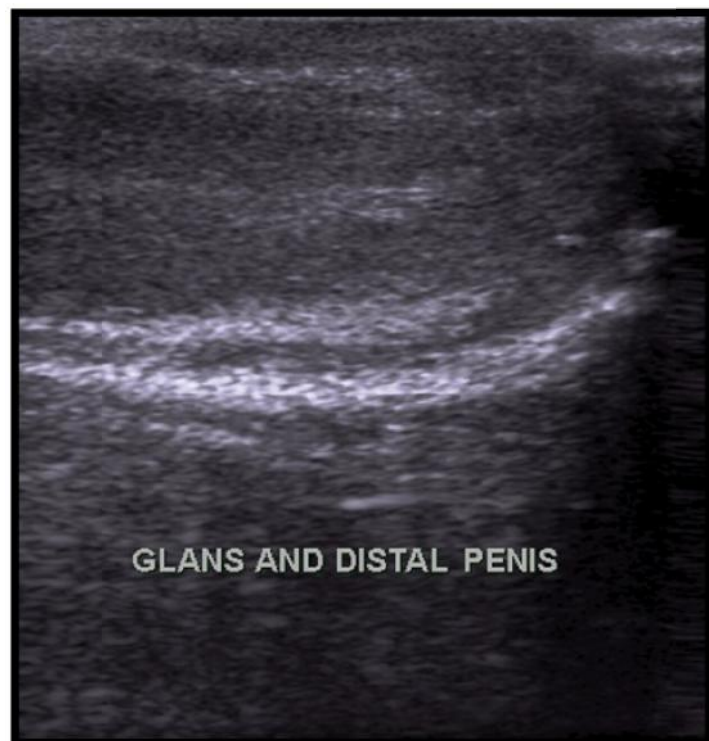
Normal sonographic anatomy of distal male penis (longitudinal view).
